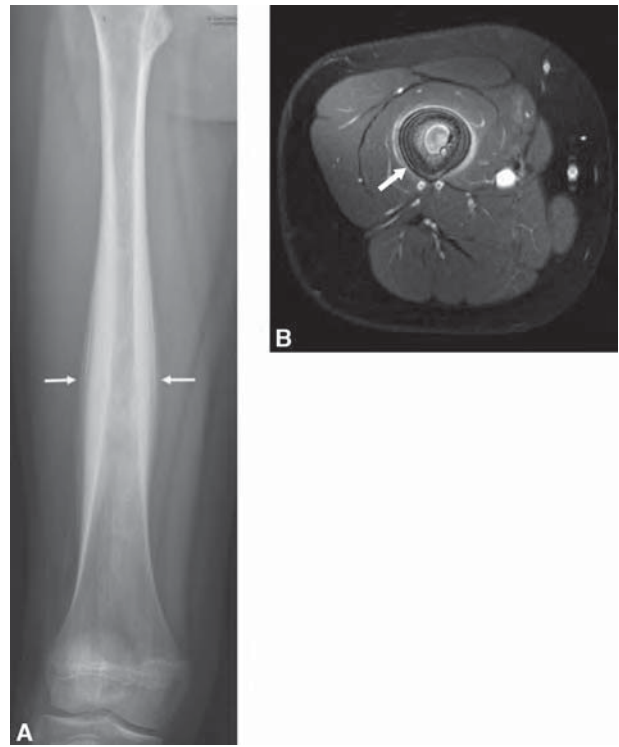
Multilamellar periosteal reaction (arrows) in a plain radiograph (A) and MRI axial T2-weighted image (B) of the femur of a young girl who presented with intermittent leg pain. Diagnostic considerations included Ewing sarcoma, osteomyelitis, osteosarcoma, and Langerhans cell histiocytosis. Open biopsy of the lesion revealed Ewing sarcoma.
